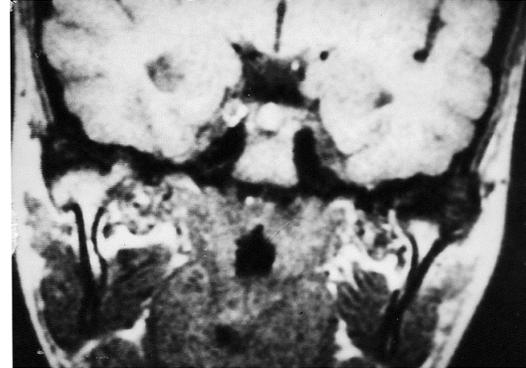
Coronal MRI revealing osteophytes in the medial aspect of the right condyle & bilateral decrease signal intensity at the superior borders of both joints
